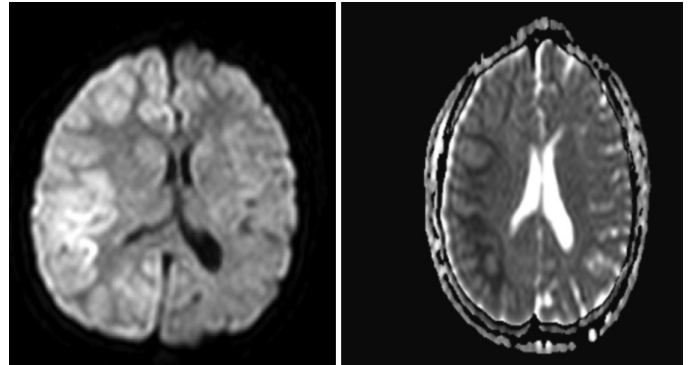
Axial diffusion-weighted MRI (DW, B100): Signal changes that are hyperintense in diffusion-weighted images and hypointense in apparent diffusion coefficient-weighted images are seen located in the posterior frontal, parietal, and temporal lobes of right cerebral hemisphere along the gyral surfaces
